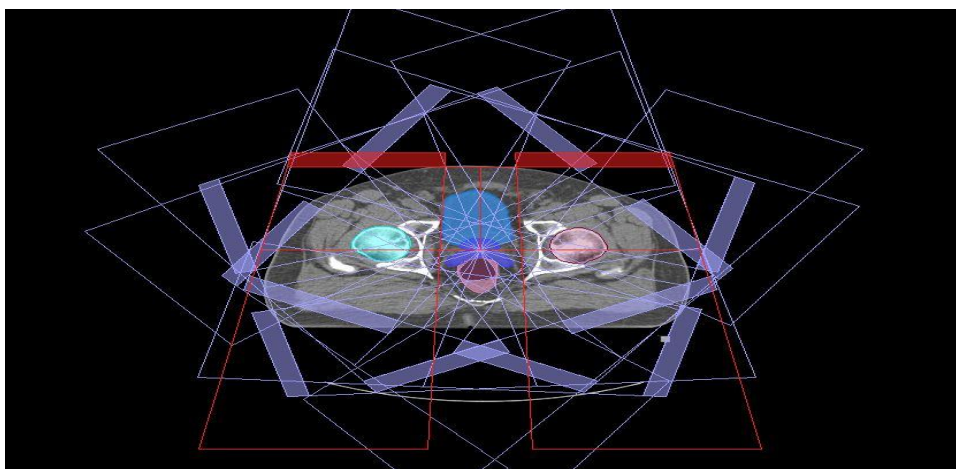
A computed tomography CT transverse plane with 7-beams arrangements for 3DCRT and IMRT plans
